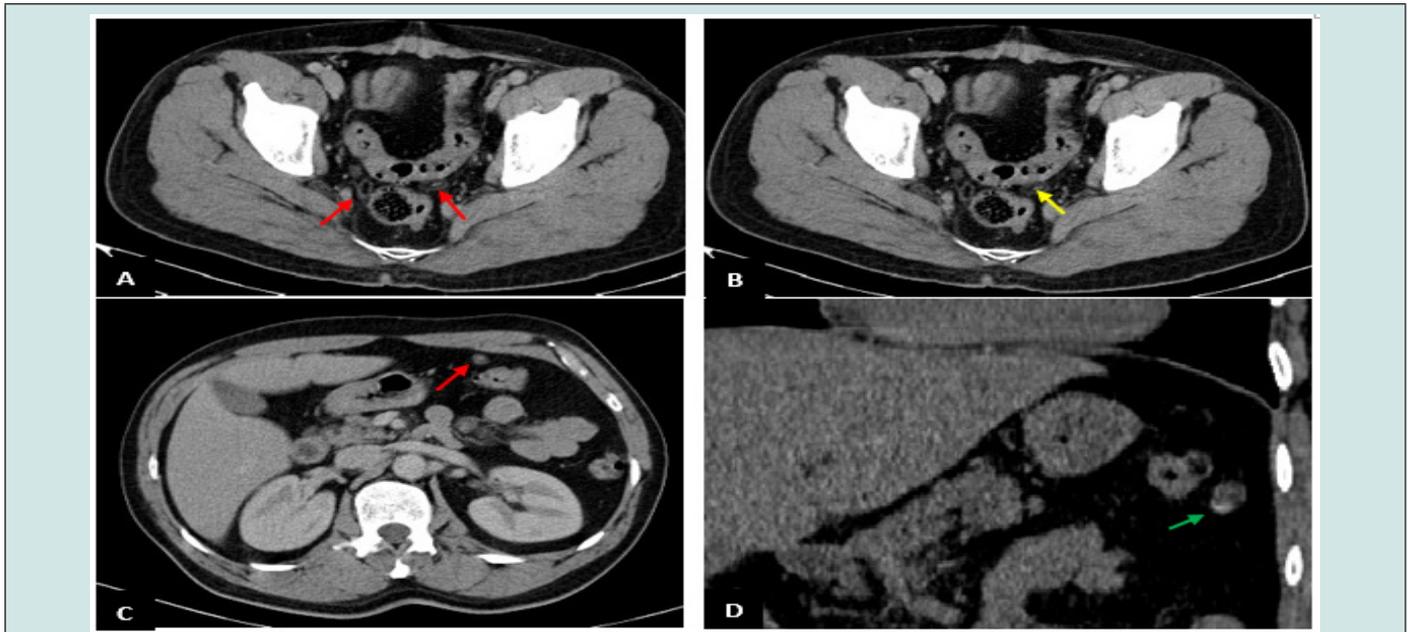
Axial slice CT images (A, B, C, D) showing fat-dense oval shuttle-shaped pericolic formations (red arrows) surrounded by a peripheral hyperdense ring giving a Ring Sign appearance. Some of them have a central hyperdensity making the Central Dot Sign appearance (yellow arrows) and others start to calcify (green arrow).
